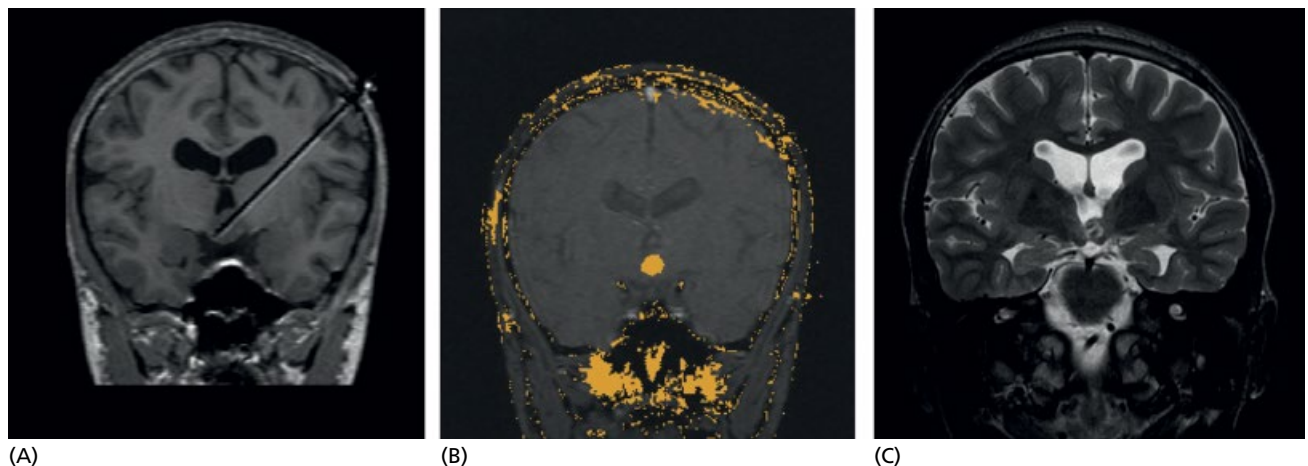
MRI of stereotactic laser ablation of hypothalamic hamartoma using laser interstitial thermal therapy for epilepsy. (A) Coronal MRI showing cannula placement before ablation on T1-weighted imaging (left). (B) The irreversible damage map (orange) superimposed upon a phase scan (middle). (C) A 3-month follow-up T2-weighted MRI showing ablated hamartoma. *Source:* Reproduced from North et al [206] with permission of Elsevier.
